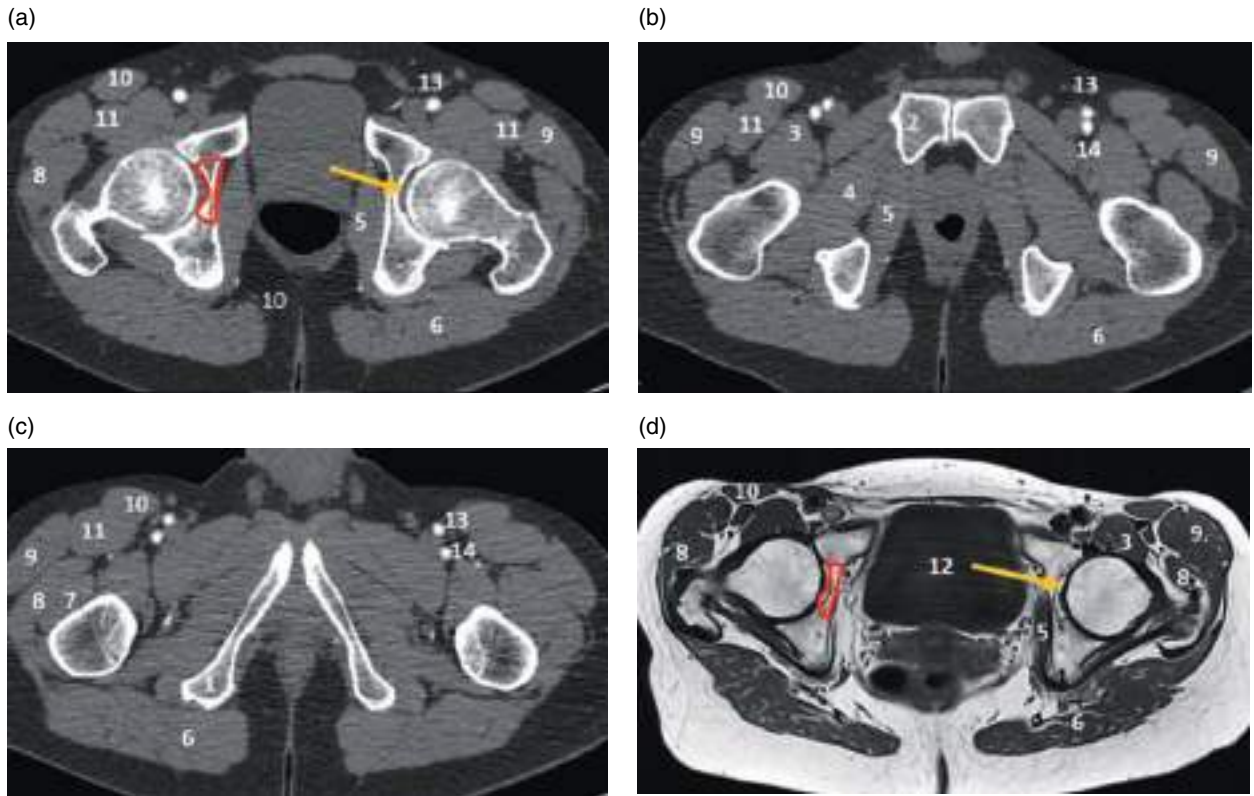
Axial CT images of the lower pelvis showing successive slices from cranial (a) to caudal (d). 1, ischial tuberosity; 2, pubis; 3, psoas iliacus muscle; 4, external obturator muscle; 5, internal obturator muscle; 6, gluteus maximus muscle; 7, gluteus minimus muscle; 8, gluteus medius muscle; 9, tensor fasciae latae muscle; 10, sartorius muscle; 11, rectus femoris muscle; 12, acetabulum; 13, femoral artery; 14, deep artery of the thigh; red area, quadrilateral plate.
